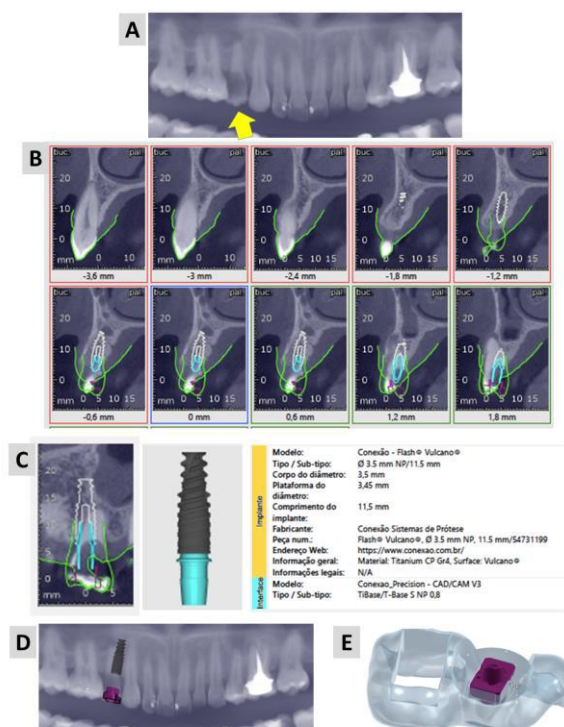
Preoperative planning for implant placement using index-guided surgery. A) Initial panoramic X-ray image showing involvement in unit 14 (yellow arrow); B) CBCT images show the virtual surgical planning of the implant with the indexed prosthetic component (ti-base) positioned in the sectional slices of the alveolar bone; C) Data obtained from the implant and the interface; D) Panoramic X-ray image of the final planning; E) Final production of the surgical guide with the Sensitive® index ring
